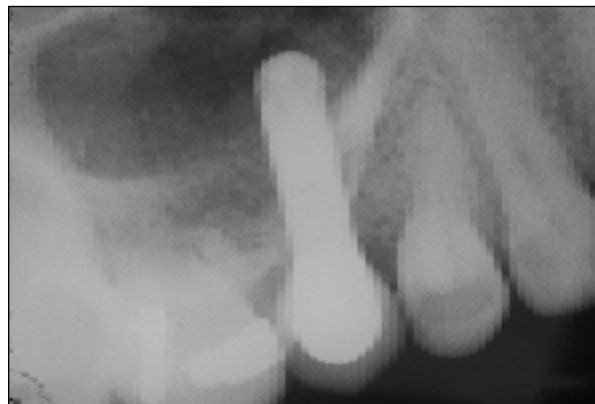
Periapical radiograph of the restored implant.
